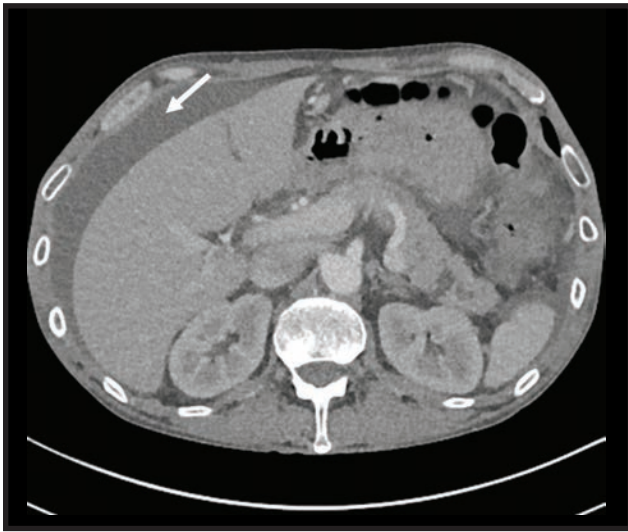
CT demonstrating new ascites in a patient found to have pancreatic ascites
